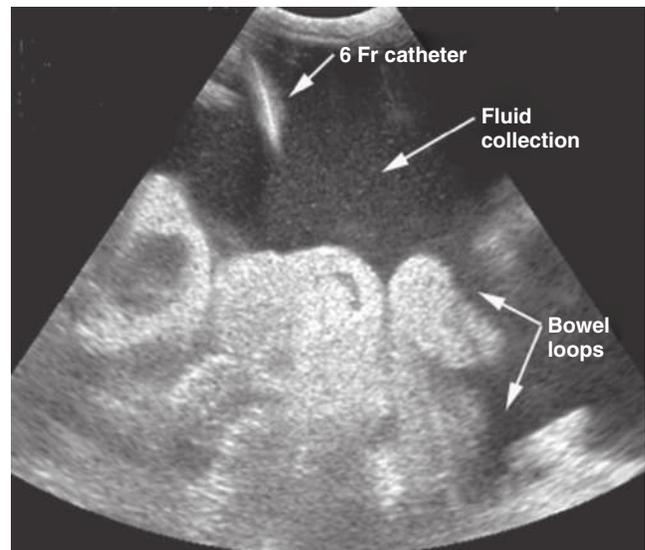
Transverse view of a left lower quadrant abdominal collection. Echogenic, particulate material can be seen floating in the collection. Loops of bowel also are well visualized. A 6F catheter was inserted under ultrasound guidance to drain the collection, which was found to be chylous. Fluid collection with echogenic material and diffuse echoes on ultrasound are suggestive of particulate matter (e.g., fibrin or clots) and may represent an exudate or blood collection. (Courtesy Dr. Kurian Puthenpurayil.)
